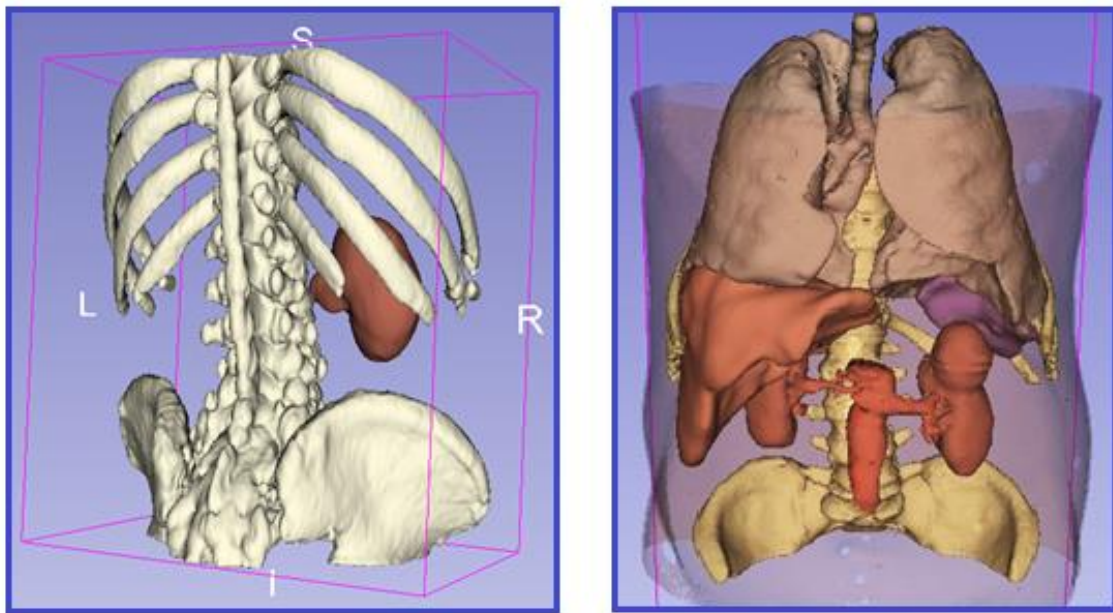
Example of scene creation and a complete 3D Abdominal Model reconstructed by a CT image given us by Niguarda Hospital
